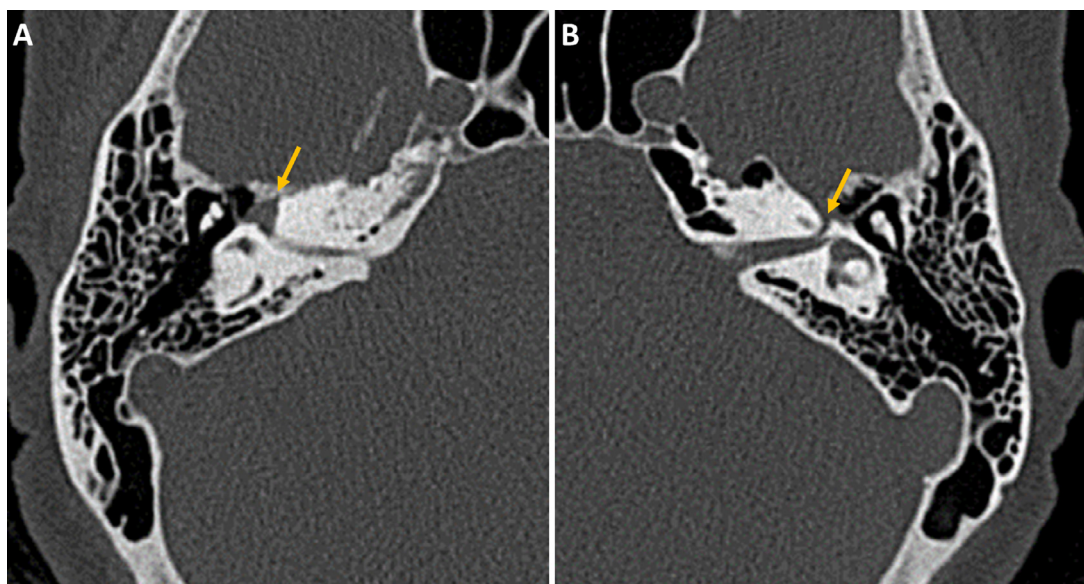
CT temporal bone, right-side (A) and normal left-side (B) in a 57-year-old woman with recurrent episodes of dizziness over 6 months. Expansion of the right geniculate ganglion (A, arrow), compared to contralateral normal left side (B, arrow).
